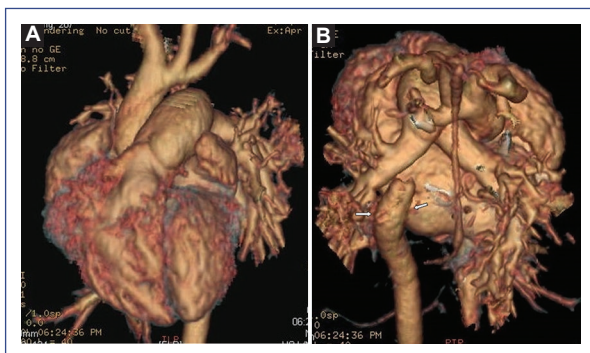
CT angiography. A: three supra-aortic vessels and interruption of the aortic arch behind the left subclavian artery are observed. B: pulmonary artery and confluent branches are shown. Connection of two small intercostal arteries (\Rightarrow) in the upper part of the descending aorta.
